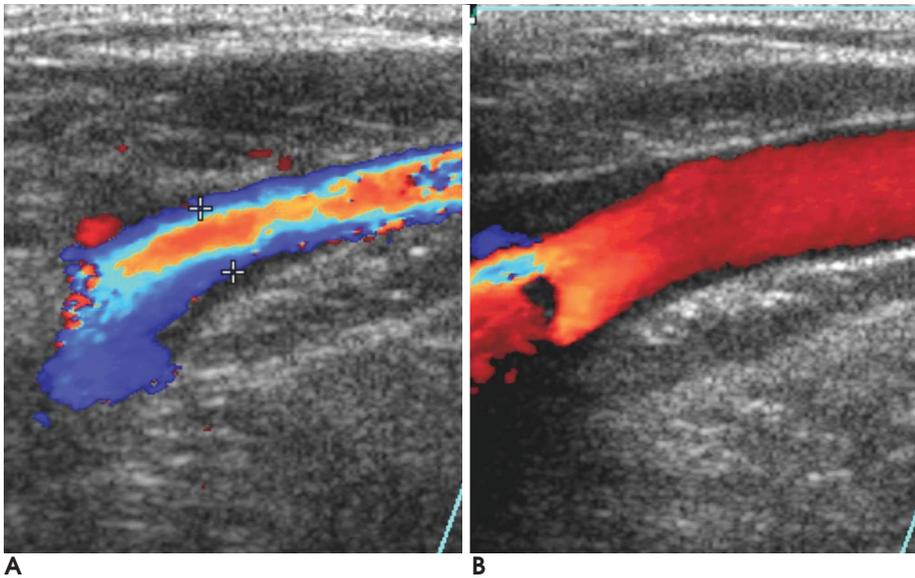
Grade III reflux : a. Color Doppler image of great saphenous vein in resting state. b. Color Doppler image with Valsalva maneuver show continuous reflux with dilatation in great saphenous vein.
